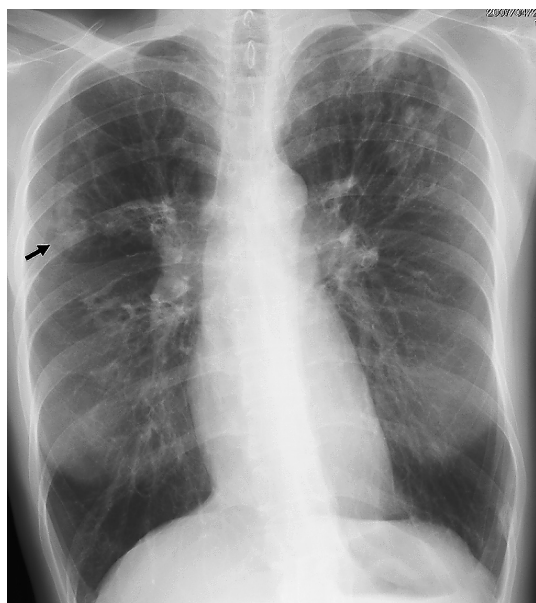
An X-ray film of the chest just before admission showed overinflation of both lungs and a newly occurred small cavity in the right upper lung field (arrow). There were no findings of exacerbation of BO itself or relapse of pneumothorax.
